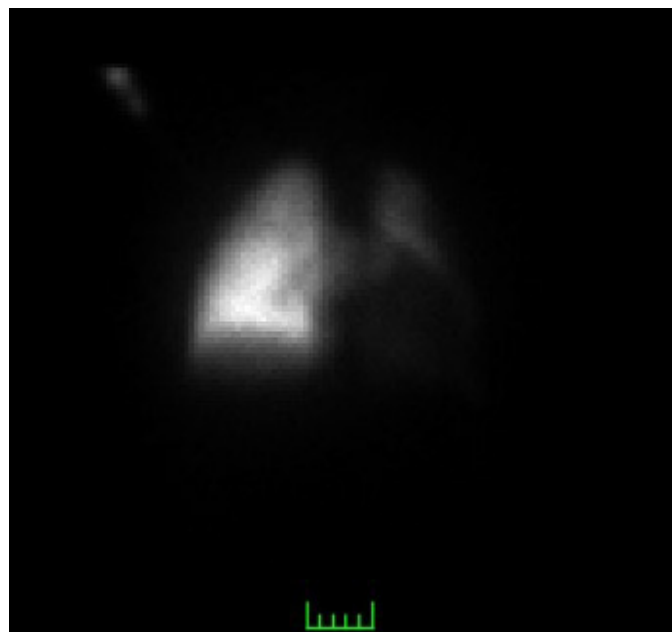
In the scintigraphy images, hypoplastic left lung with subsegmental hypoperfusion and compensatory hypertrophic right lung with normal perfusion were observed
